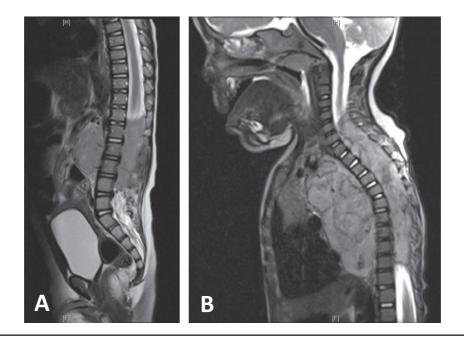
A, Case 1, T2-weighted sagittal magnetic resonance imaging demonstrating multilevel infiltration into the spinal canal from L1/2-L4/5 with intraspinal extension to the T11/12 level. B, Case 2, T2-weighted sagittal magnetic resonance imaging demonstrating multilevel thoracic intraspinal extension.
